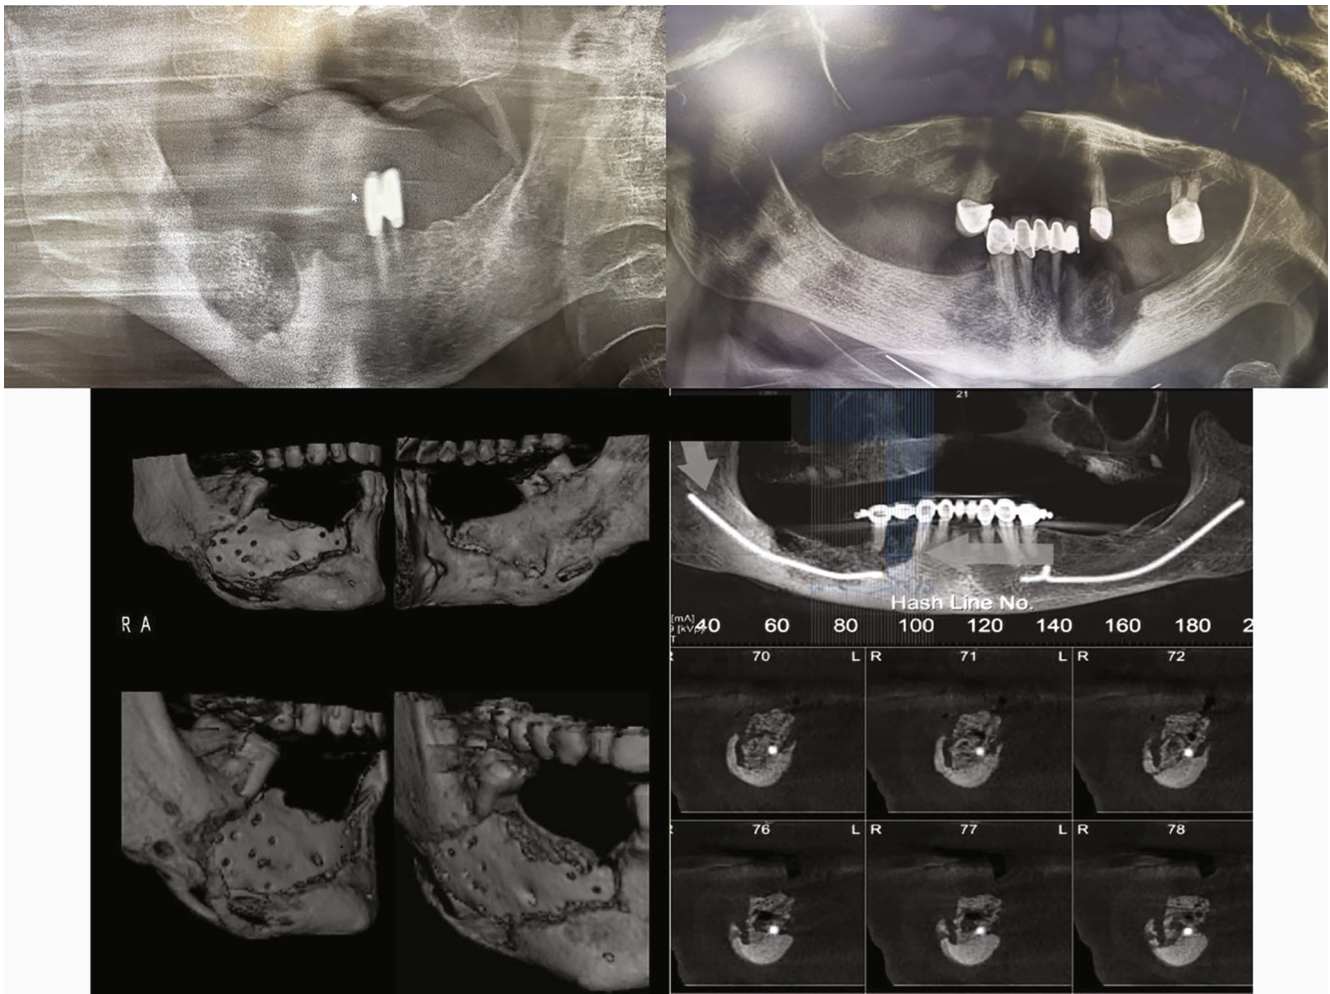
Panoramic and cone beam computed tomography images of MRONJ.
